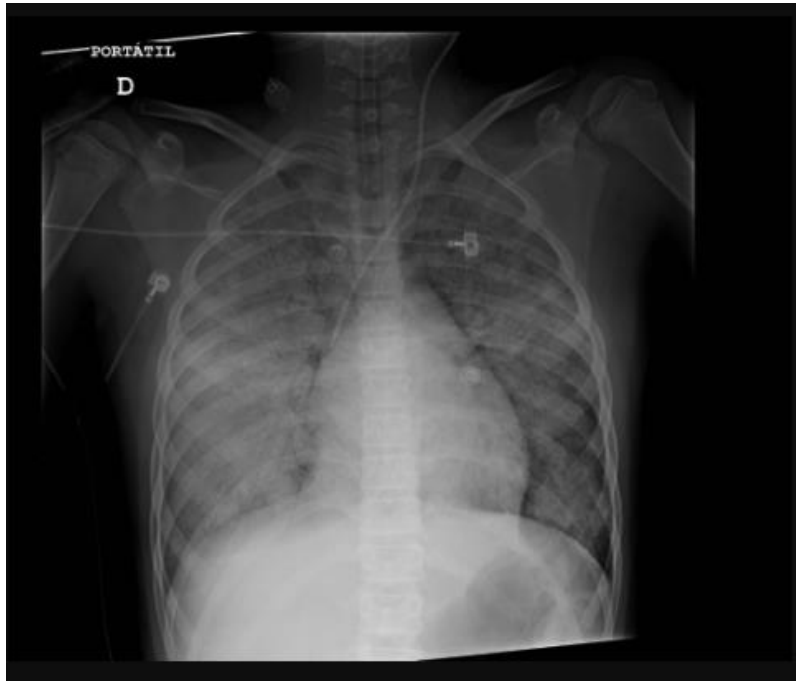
Chest X-ray Generalized interstitial infiltrate compatible with acute pulmonary edema. Left jugular venous catheter with a tip in the superior vena cava. Endotracheal tube 2 cm from the carina. Nasogastric tube in gastric chamber.
